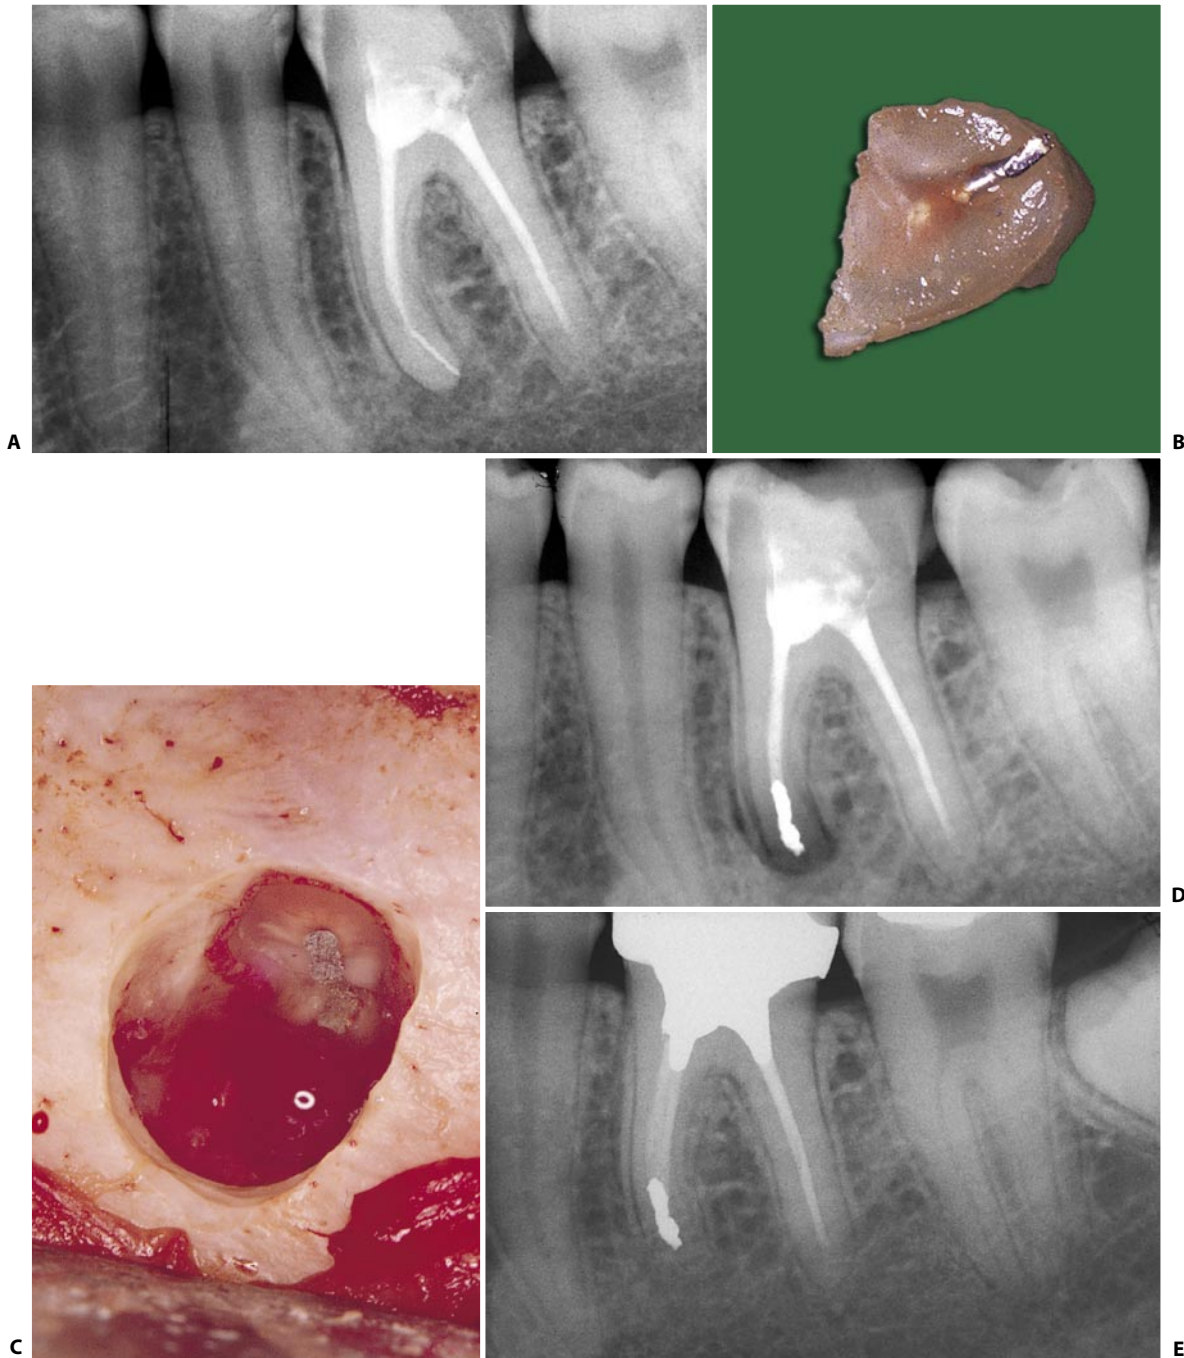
A. Preoperative radiograph of the mandibular first molar showing a fragment of a broken instrument at the apex. B. Sectioned apex containing a fragment of Hedstroem's file. C. The root has been bevelled and the two canals filled with a single amalgam filling. D. Postoperative radiograph. E. Eighteen months later.
